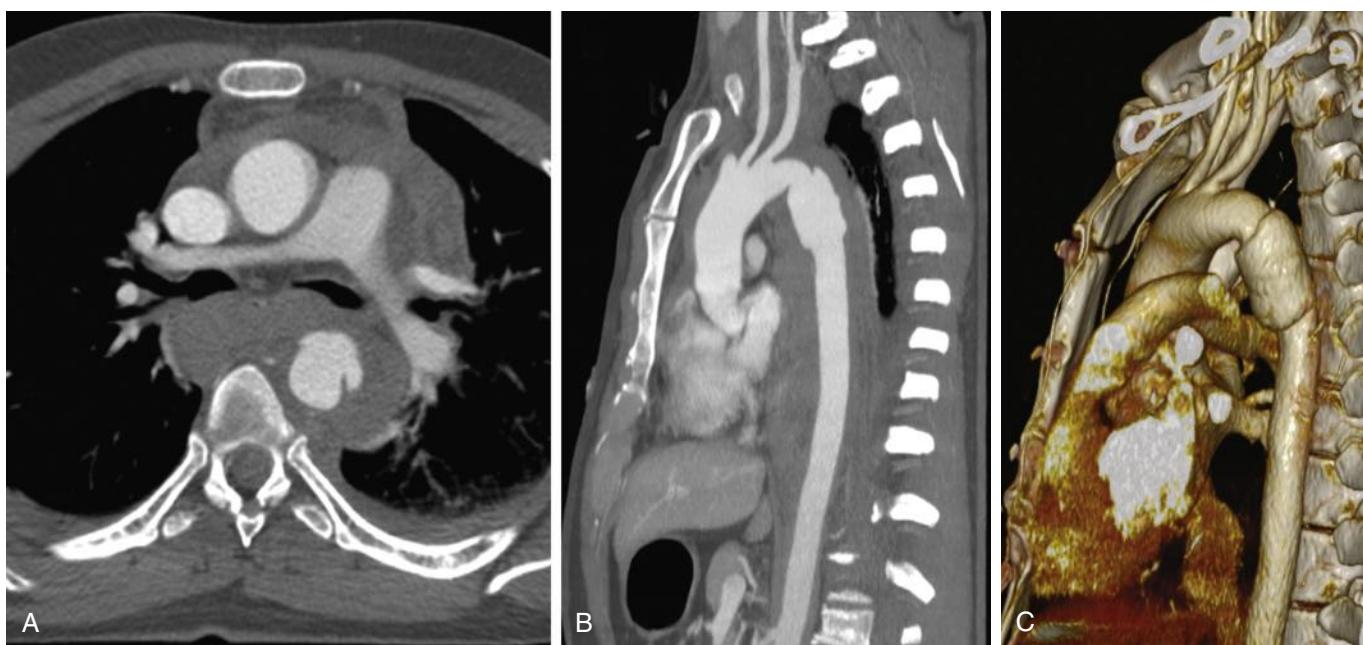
Computed tomography angiography of a patient with blunt thoracic aortic injury. (A) Axial view demonstrating the injury and periaortic hematoma. (B) Sagittal view demonstrating the typical location of the injury at the isthmus distal to the left subclavian artery. (C) Three-dimensional computed tomography reconstruction.
